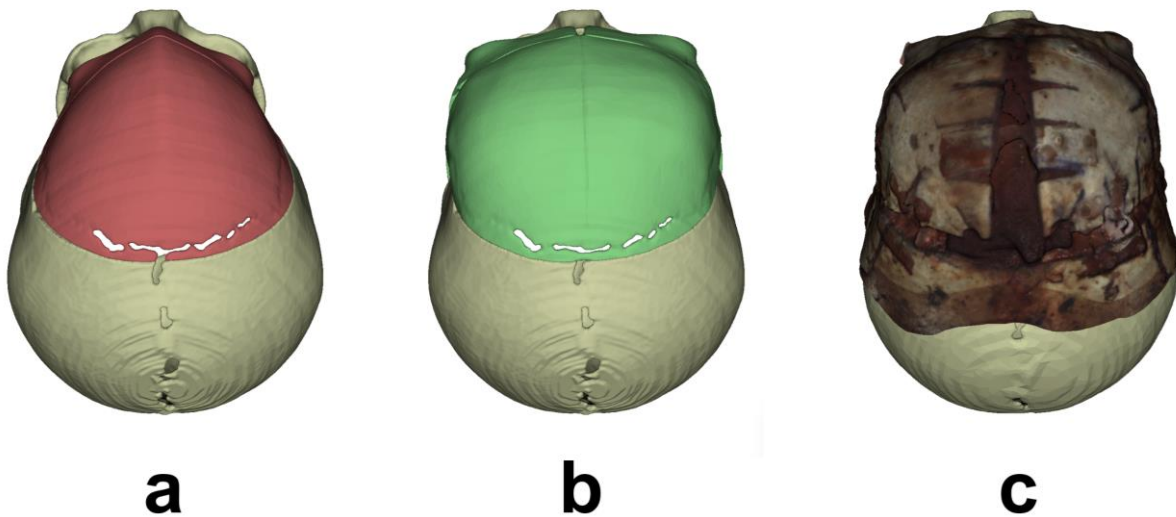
Superior view of (a) preoperative bone 3D model obtained from CT scan, (b) virtual surgical plan, and (c) postoperative bone 3D photograph.
